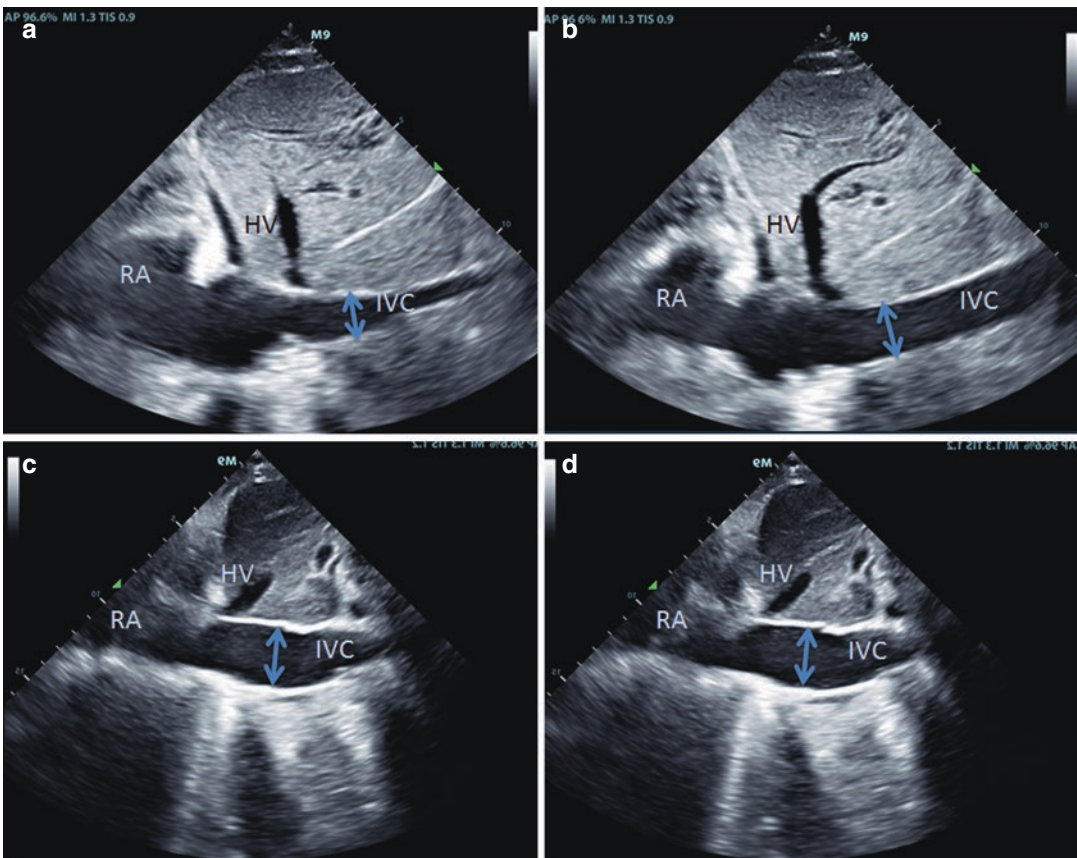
IVC variation during respiration (transthoracic echocardiogram, subxiphoid view). a vs. b: roughly 50% IVC variation, suggests volume responsiveness. c vs. d:
